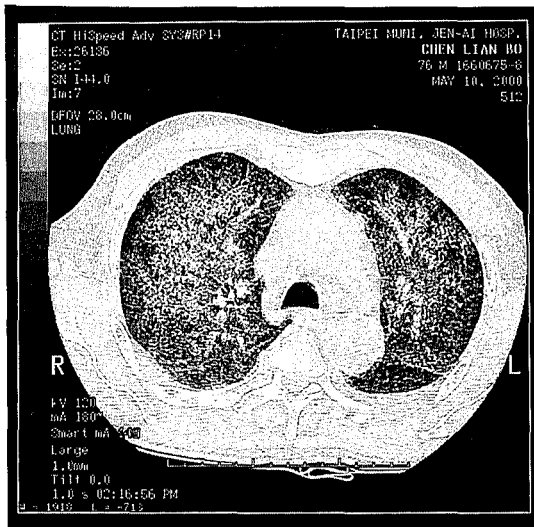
Ground-glass patches with several reticulonodular centrilobular opacities were disclosed in thoracic high resolution CT.
